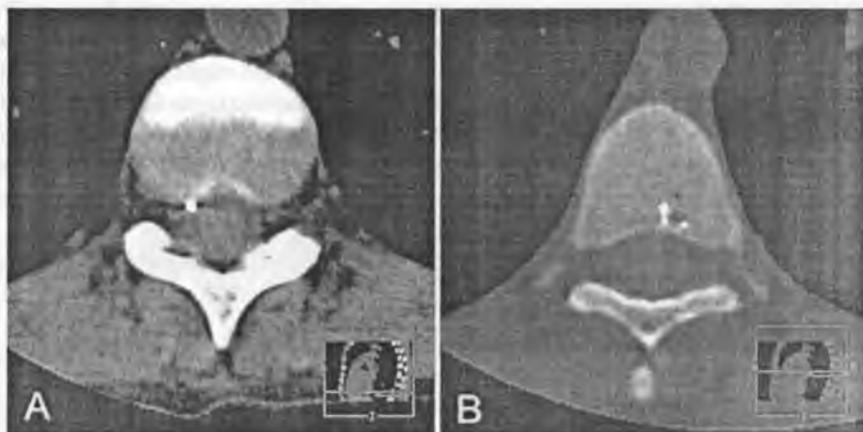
Computed tomography, axial projections; A) Single metallic grain in the vertebral canal; B) Particles of mercury in the course of nutrient canal of the vertebra
